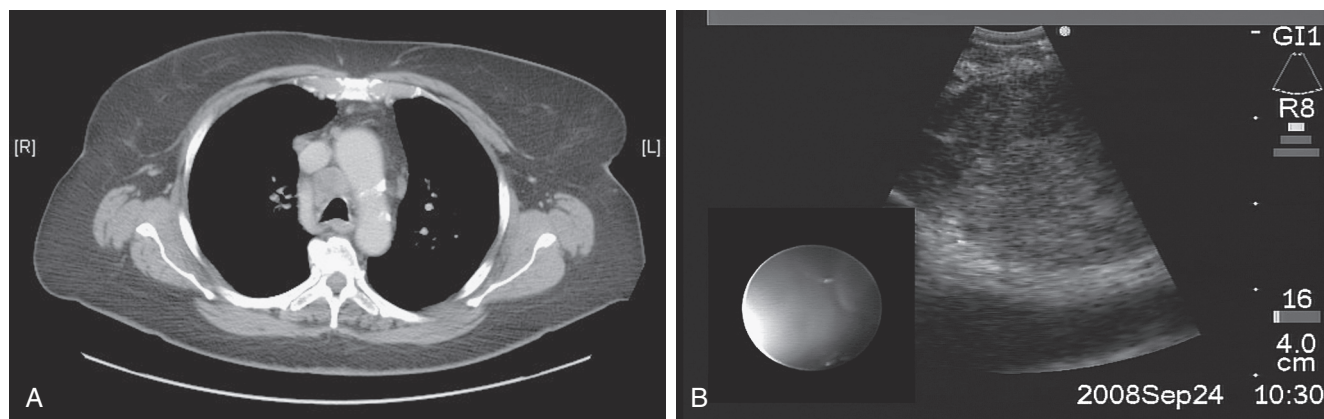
■ A, CT scan of the chest revealing enlarged right paratracheal lymph node. B, Endobronchial ultrasound (EBUS)-guided transbronchial needle aspirate of an enlarged right paratracheal lymph node.
